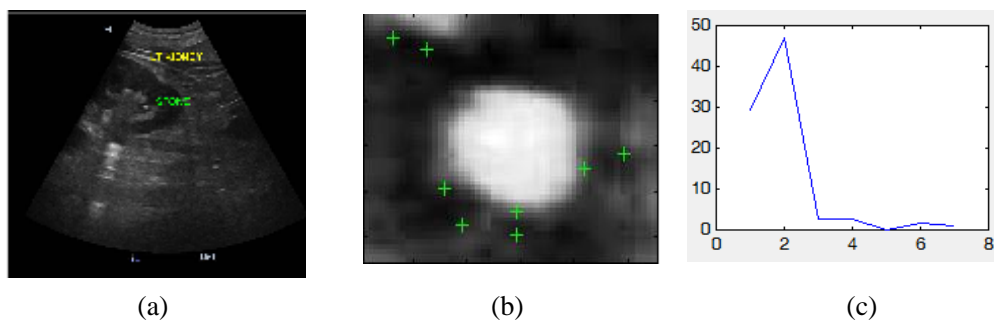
Ultrasound image. b) SIFT key points. c) SIFT Features
